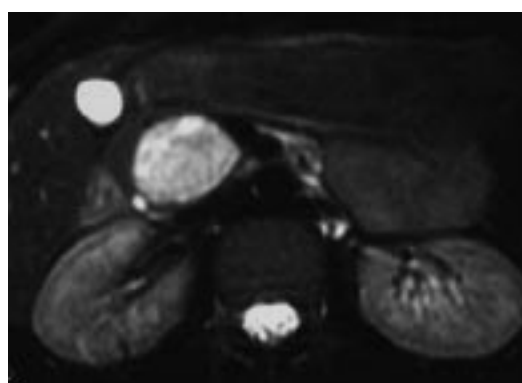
T2-weighted axial MR image shows that the mass is predominantly hyperintense mostly composing of solid compounds and minimal cystic areas.
